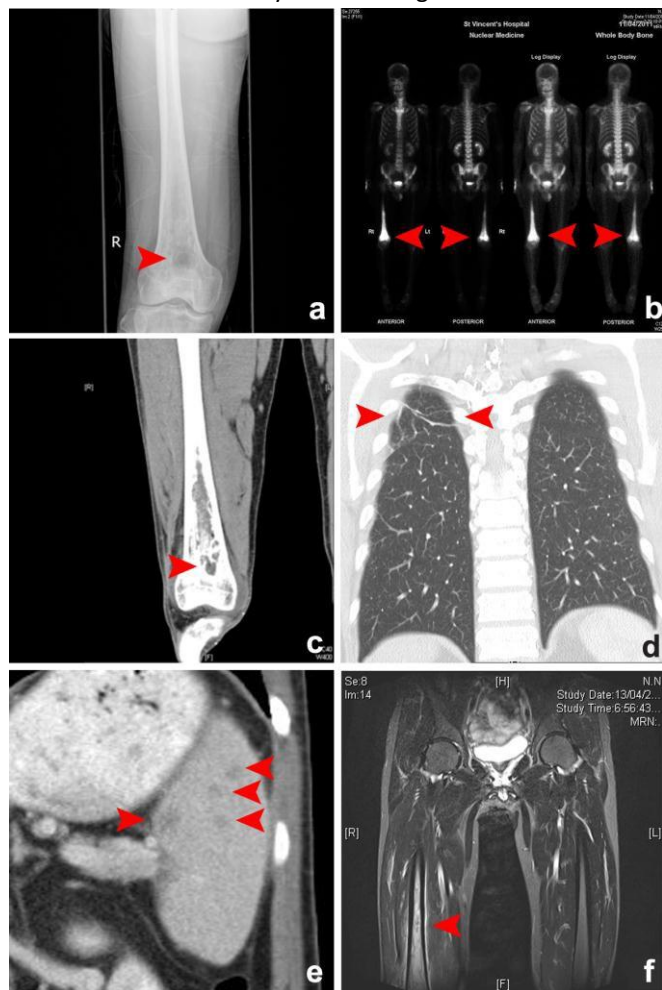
(a) Plain X-ray right femur showing a lytic lesion within the medulla. (b) Bone scan showing non-specific focal uptake within the right femur. (c) Computed tomography (CT) right femur showing a multiloculated lytic lesion within the medulla. (d) CT chest showing right upper lobe fibrosis. (e) CT abdomen showing multiple splenic hypodensities suggestive of pyogenic abscesses. (f) Magnetic resonance imaging (MRI) right femur showing extensive necrotic areas secondary to osteomyelitis involving the femoral shaft.
